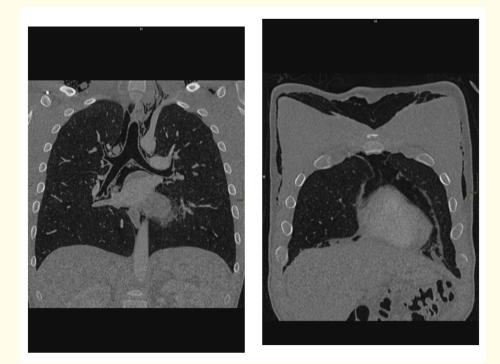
Non-contrast Coronal CT Multi-planar reformats (MPRs) confirm extensive pneumomediastinum, pneumopericardium and widespread subcutaneous emphysema. The pneumomediastinum outlines the central bronchial tree as well as the major hilar vessels.
